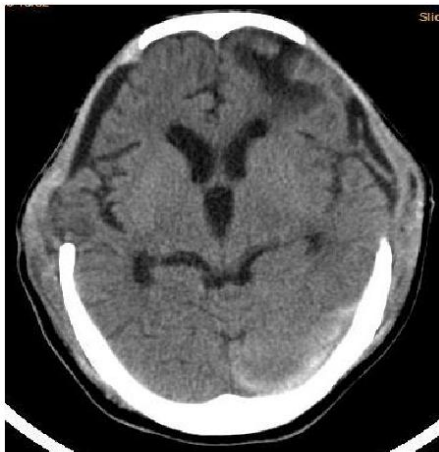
Axial CT scan of brain with bilateral calvarial defects at the time of discharge from the hospital. Noted on the left frontal region is the loss of parenchyma and bilateral subdural hygromas and mild dilatation of ventricular system.
